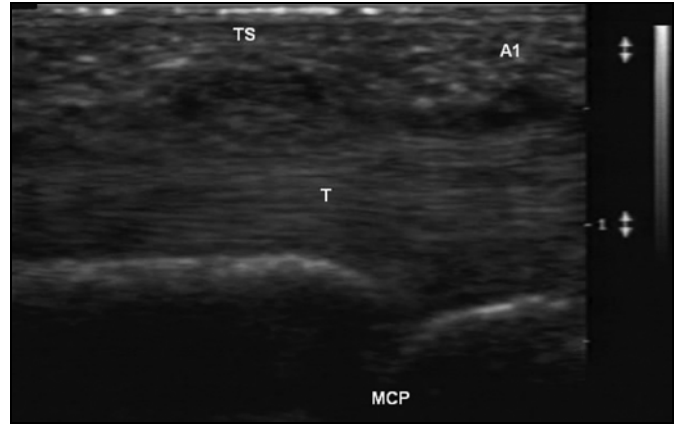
Trigger finger. Longitudinal sonogram of trigger finger at level of metacarpophalangeal (MCP) joint shows focal tenosynovitis (TS) on palmar aspect of flexor tendon (T) and thickened A1 pulley. There is hesitation of flexor tendon movement during extension. For video, see supplemental Figures S3A (normal) and S3B (trigger finger).
